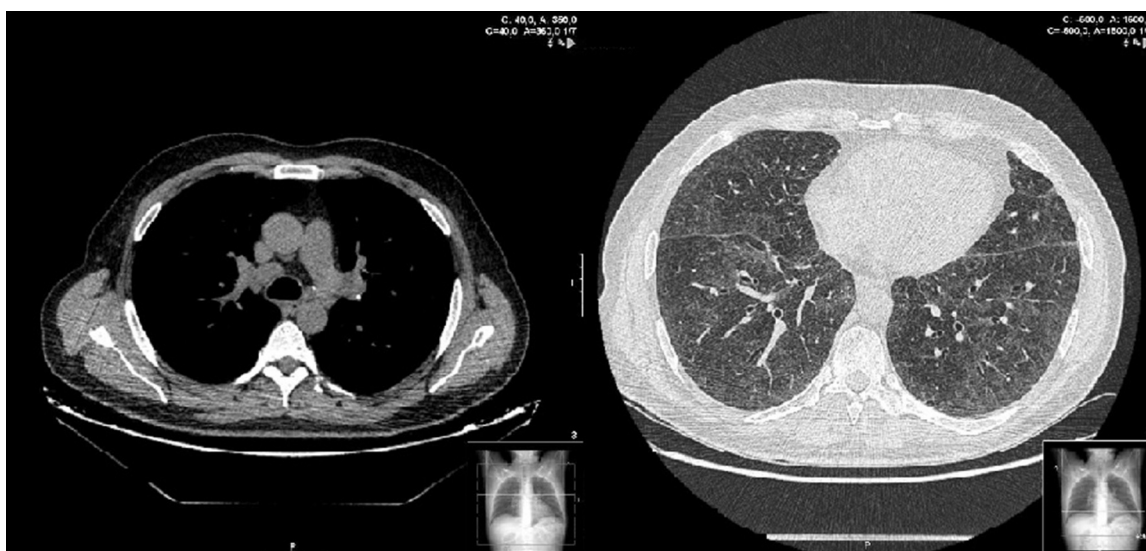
Sarcoidosis in 50 years-old man, coinfecting with HIV and HCV, and treated with telaprevir-based triple therapy. Thin-section of thoracic CT shows bilateral and diffuse ground-glass opacities, and multiple centrilobular micronodules.
